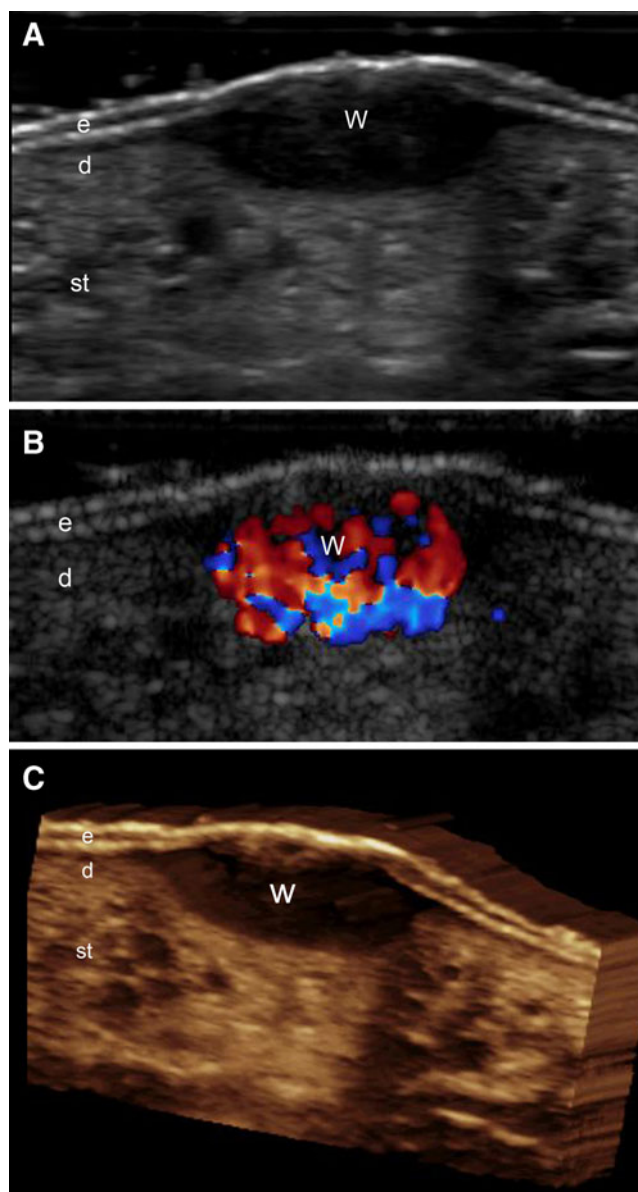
(A-C) Plantar wart. A Ultrasound (transverse axis) shows a fusiform hypoechoic lesion that involves the epidermis and dermis. B Color Doppler ultrasound (transverse axis) demonstrates increased blood flow within the dermis and sublesional subcutaneous tissue. C Ultrasound 3D image of the plantar wart (5-seconds sweep through the lesional skin). Abbreviations: *W* wart, *e* epidermis, *d* dermis, *st* subcutaneous tissue
